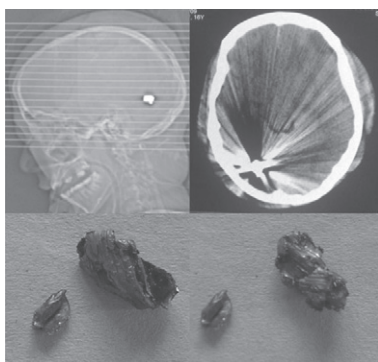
The deformed and mushroomed splinters removed from the occipital lobe of a blast-injury patient seen in X-ray skull and plain cranial CT.
